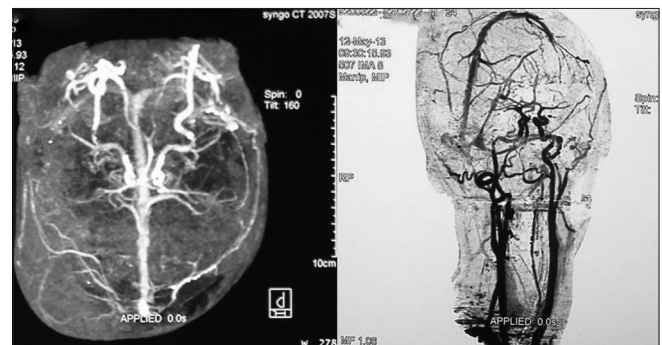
Postoperative computed tomography angiography of cerebral vessels showed no vascular abnormality
